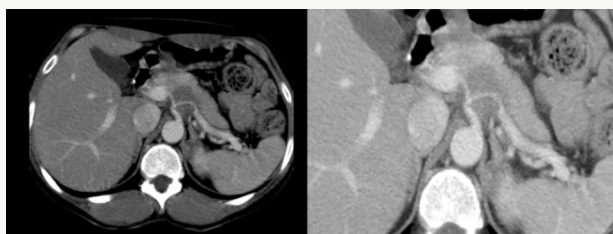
Contrast-enhanced CT showed a nodule in the body of the pancreas 2.6x2.4 cm involving the bifurcation of the celiac axis
